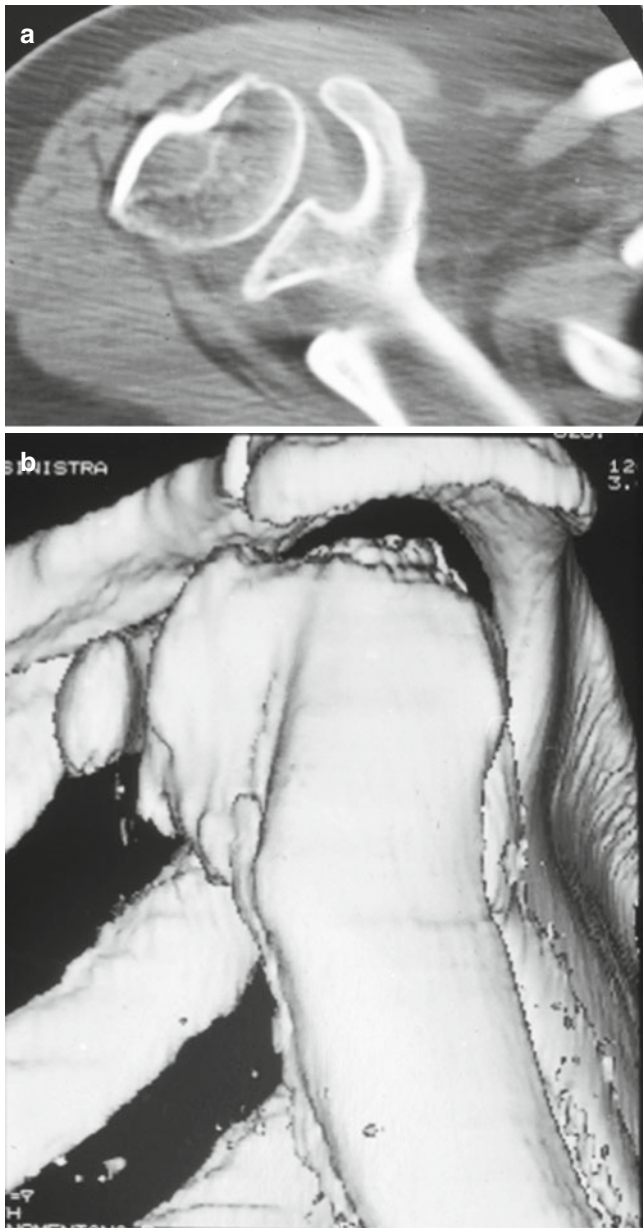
(a, b) CT exam performed on the left shoulder of a male patient with congenital deformity of the humeral head and with a pathological narrowing of the subcoracoid space
